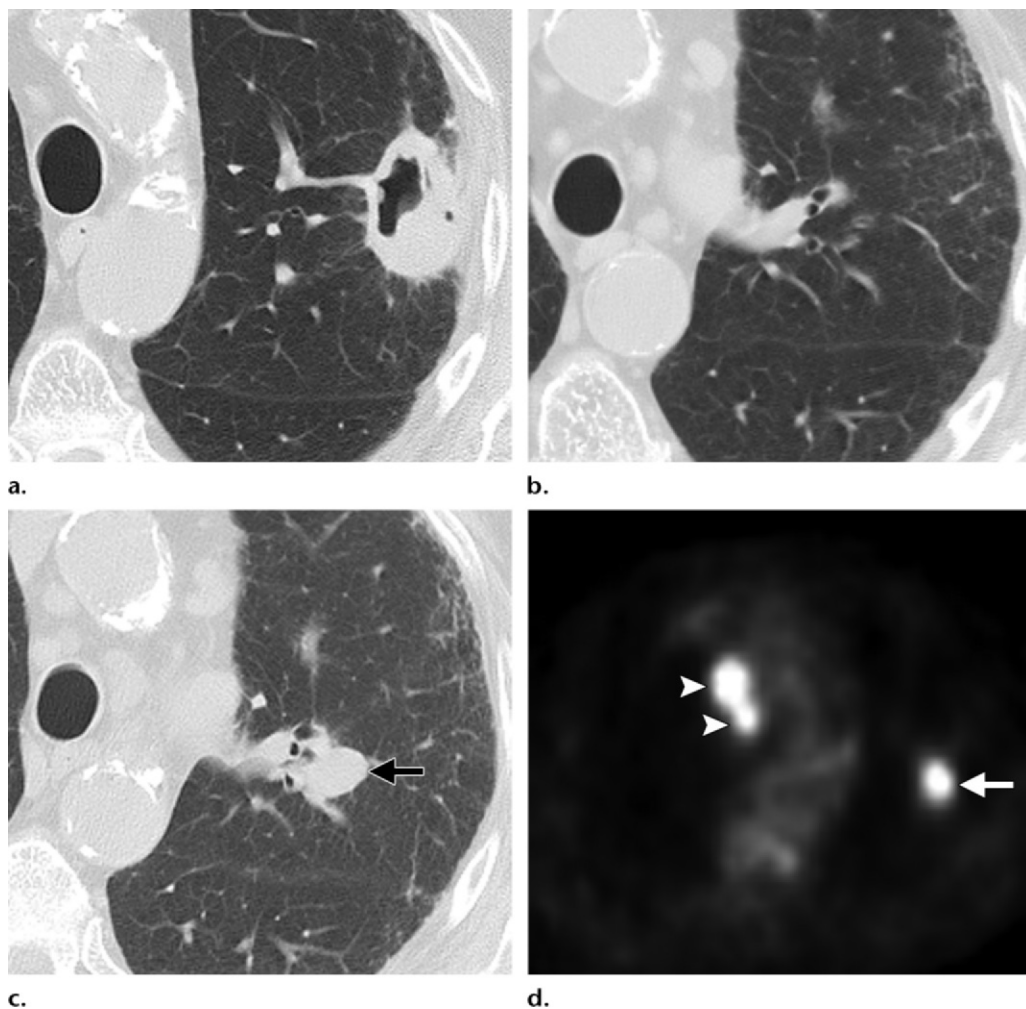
Non-small cell lung carcinoma in the left upper lobe in a 73-year-old woman. (a, b) CT images at the level of the ablated mass (a) and at the level of the left lobar lymph nodes (b) obtained at 1 month after RFA show no evidence of local adenopathy. (c, d) CT (c) and PET (d) images obtained at 6-month follow-up show a left lobar well-defined local-regional lymph node (arrow), as well as right paratracheal lymph nodes (arrowheads in d) with hypermetabolic activity, findings that are consistent with metastasis.
